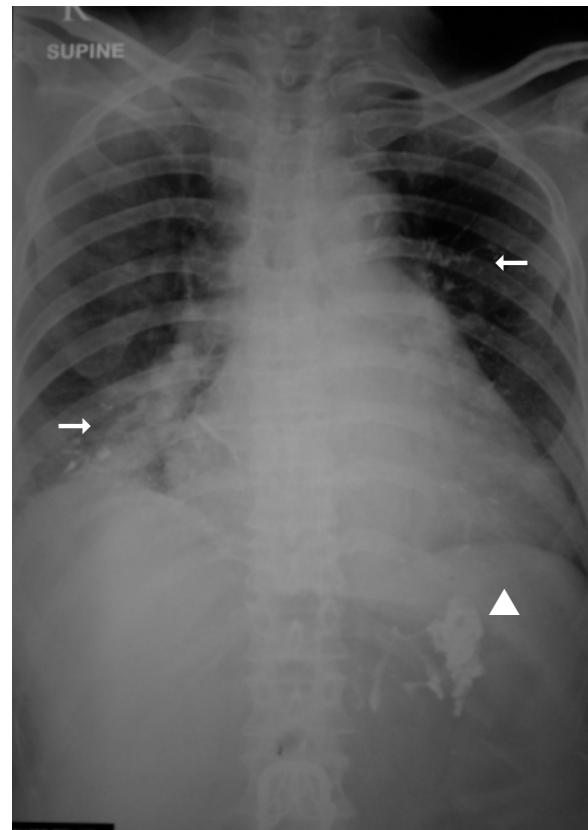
Chest radiograph after glue injection showed enlarged cardiac size and pulmonary trunks with small opacities in both lungs (arrow). The opacities from the site of injection were detected in the area of gastric varices (arrowhead).
